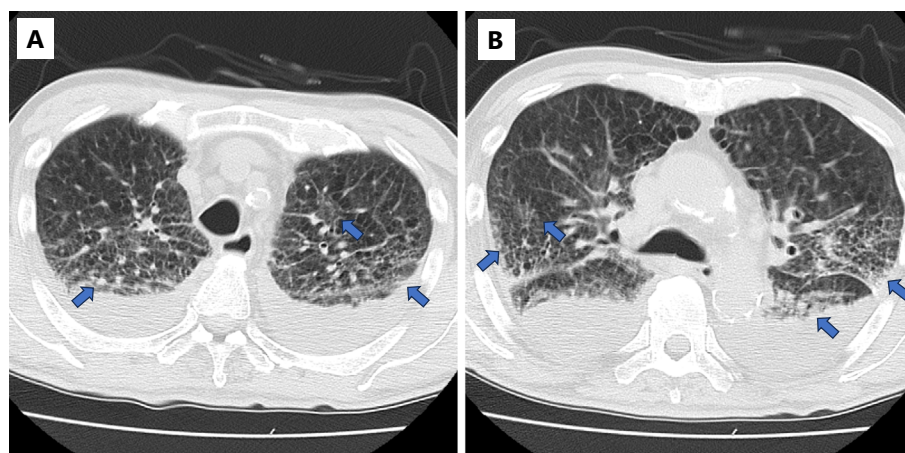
Axial CT images of the upper (A) and middle (B) lung fields of the patient in Case 2. There were bilateral pleural effusions and diffuse thickening of the interlobular septal wall in both lungs (arrows). The lungs also showed the preexistence of background emphysematous changes.
